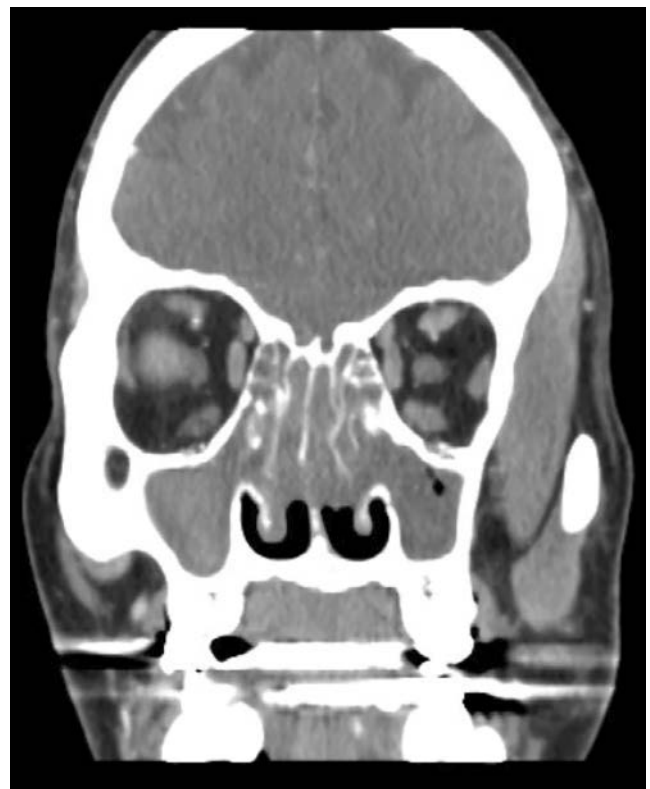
Sinus computed tomography scan revealing severe pansinusitis with dense material in the right maxillary and sphenoidal sinuses, along with severe mucosal disease and opacification of the maxillary sinuses, ethmoid cells, sphenoid sinus, and frontal sinus.
